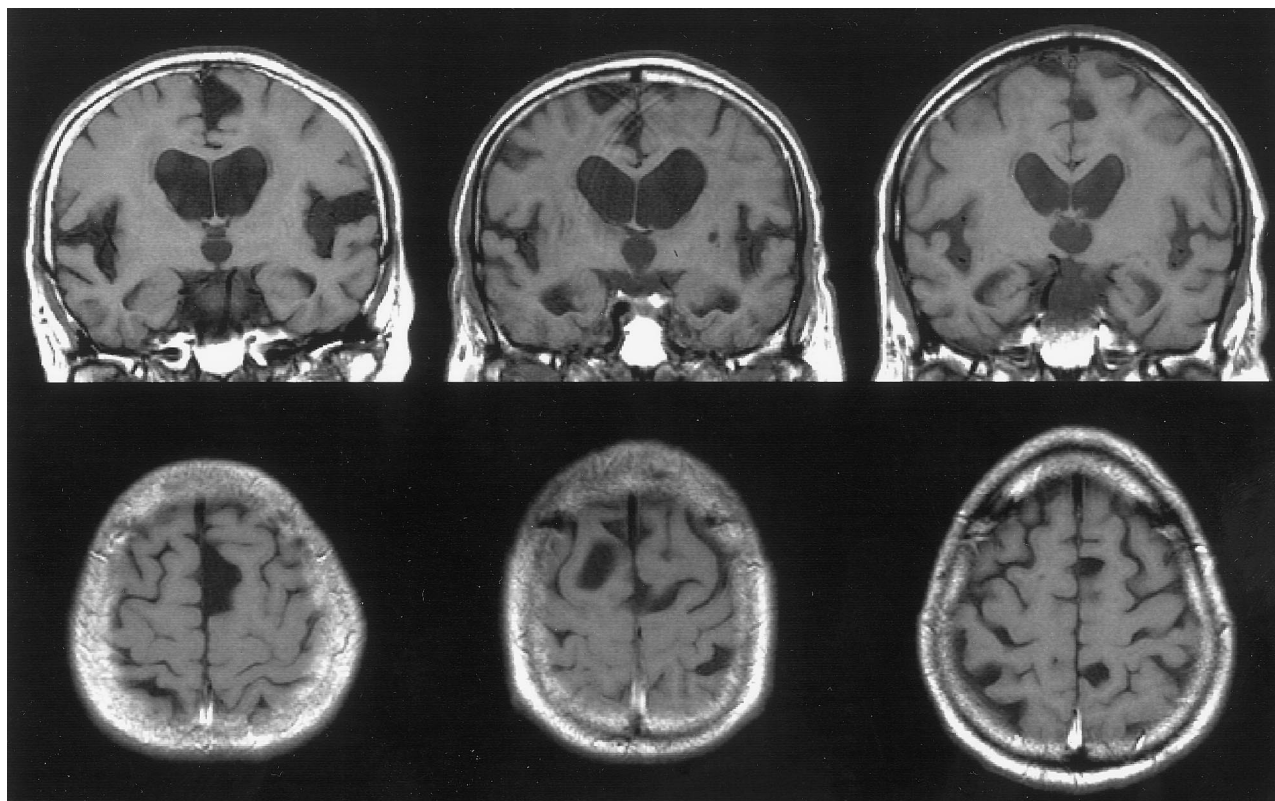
Focally dilated sulci in patients with idiopathic NPH (patients 2, 6, and 7, respectively). Coronal and axial T1-weighted MR images (550/15/4) show focally dilated sulci over the frontal convexity and medial surface, as well as enlarged ventricles, expanded sylvian fissure and basal cistern, and constricted convexity and medial surface sulci.
